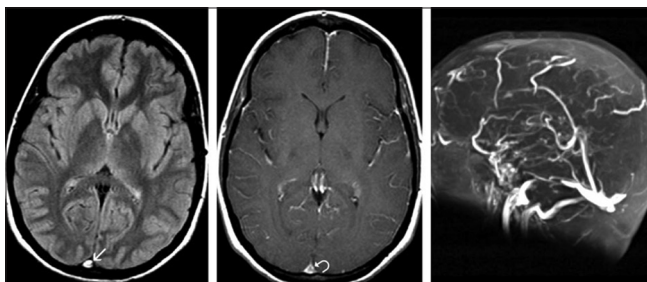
Axial fluid-attenuated inversion recover magnetic resonance imaging (MRI) show high signal intensity in the superior sagittal sinus (arrow). Axial gadolinium-enhanced T1-weighted MRI shows a filling defect (empty delta sign) (arrow) in the superior sagittal sinus. On a three-dimensional time of flight MR venogram, the superior sagittal sinus is not visualized because of extensive thrombosis
